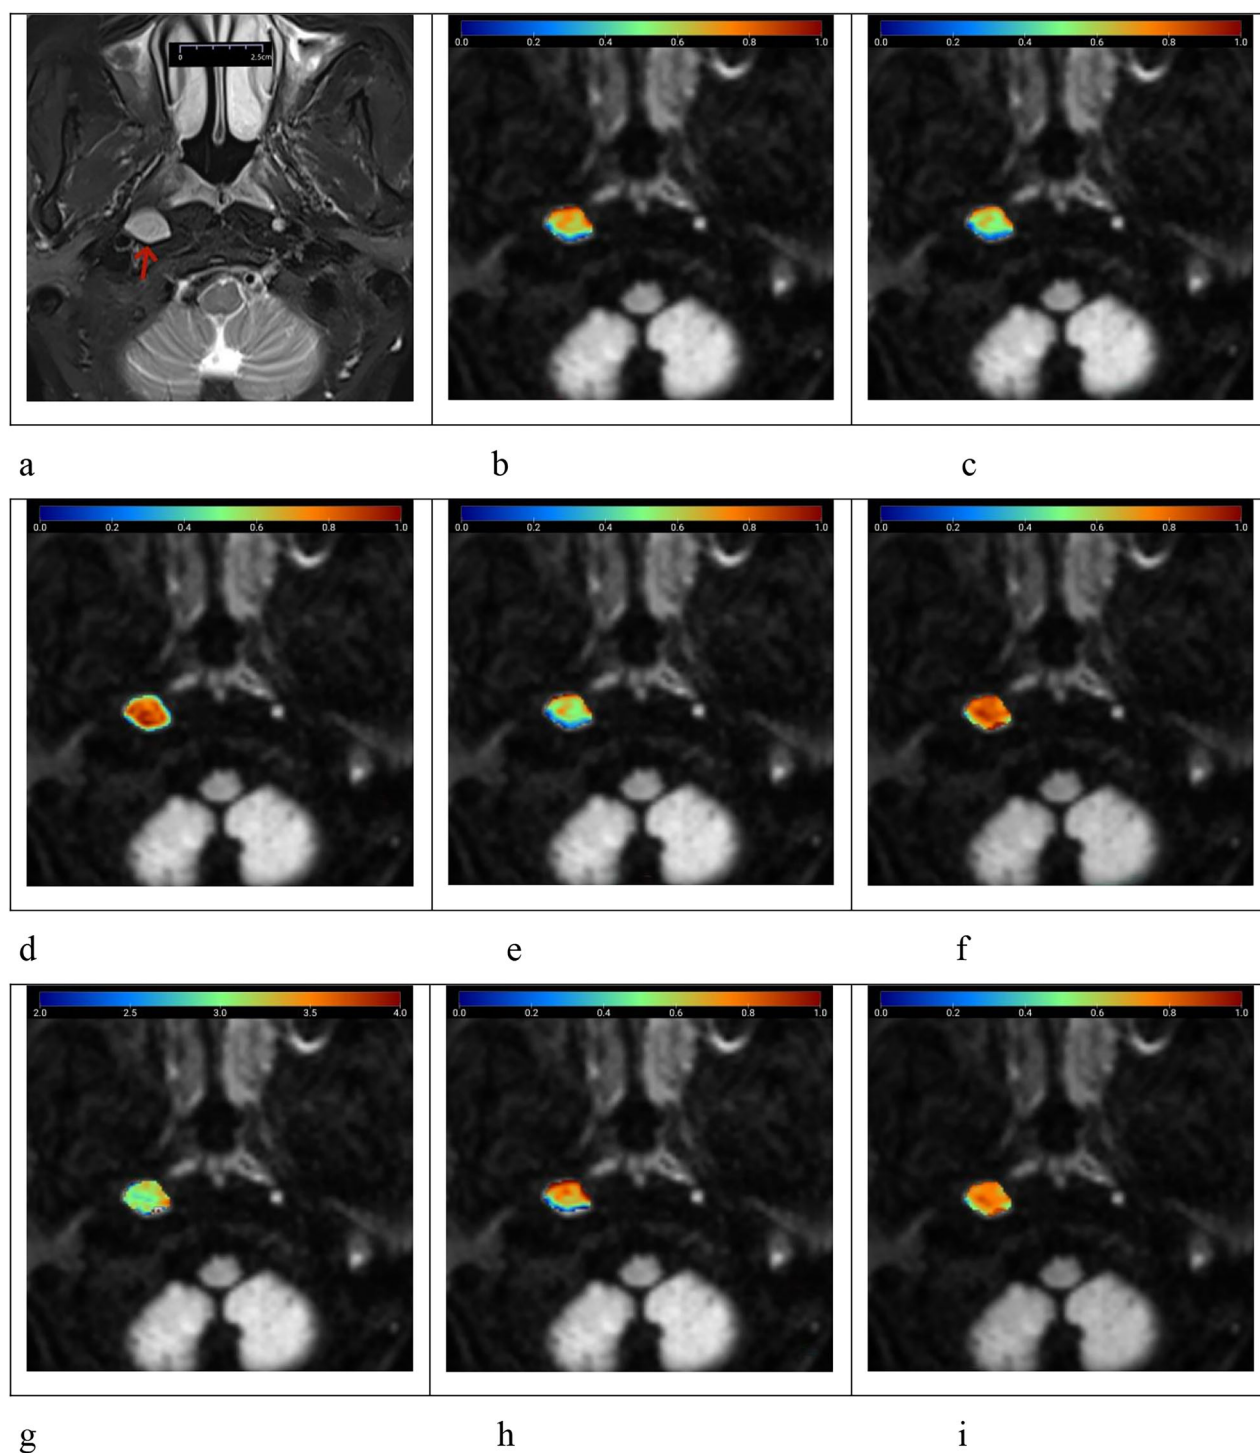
Female patient, aged 45 years, with nasopharyngeal lymphoid hyperplasia and Epstein–Barr virus positivity, presenting with a benign right retropharyngeal lymph node (arrow). a T2-weighted imaging with fat saturation shows the lymph node with a maximum axial diameter of 1.58 cm and minimal axial diameter of 1.14 cm, exhibiting a homogeneously slightly high signal. b–i Pseudocolor maps of the quantitative parameters $ADC = 0.678 \mu m^2/ms$ (b), $DDC_{SEM} = 0.616 \mu m^2/ms$ (c), $\alpha_{SEM} = 0.740$ (d), $D_{FROC} = 0.597 \mu m^2/ms$ (e), $\beta_{FROC} = 0.815$ (f), $\mu_{FROC} = 3.289 \mu m$ (g), $D_{CTRW} = 0.721 \mu m^2/ms$ (h), and $\beta_{CTRW} = 0.772$ (i), derived from conventional DWI, SEM, FROC, and CTRW diffusion models. ADC, Apparent diffusion coefficient; CTRW, Continuous-time random walk; DDC, Distributed diffusion coefficient; DWI, Diffusion-weighted imaging; FROC, Fractional-order calculus; SEM, Stretched-exponential model
